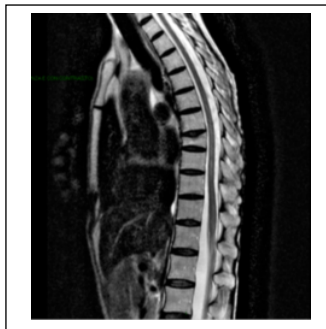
B: dorsal T2-weighted MRI.
